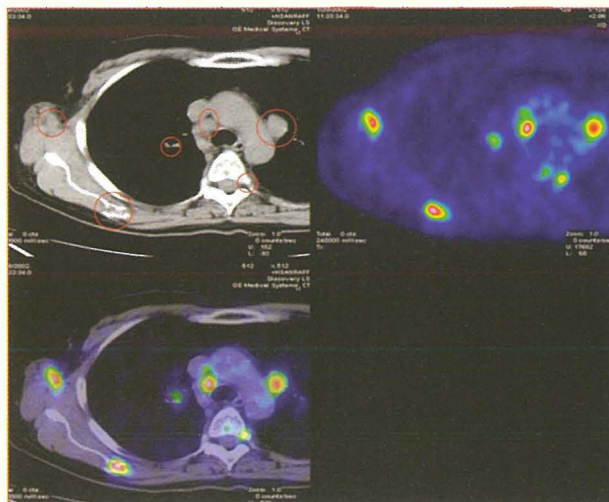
Staging and re-staging using ¹⁸F-FDG. Metabolic PET image superimposed on CT image helps the nuclear physician to report with confidence (Images courtesy of HSR, Milano)
